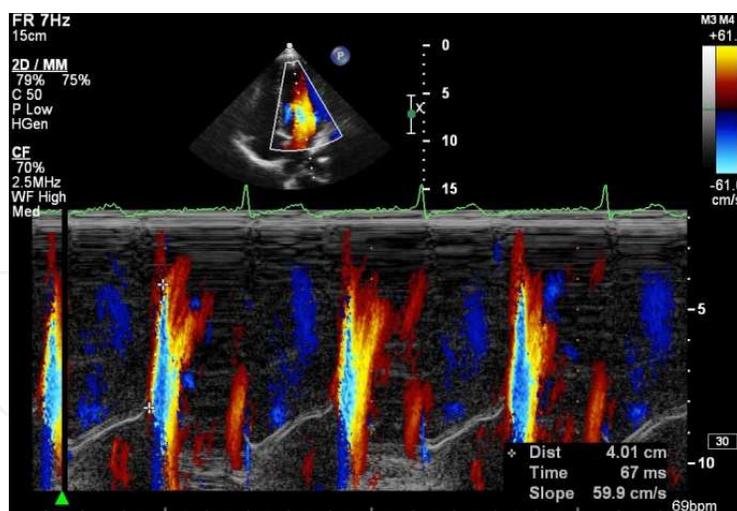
Color M-mode Doppler flow velocity propagation V_p , measured as the first color aliasing from mitral annulus to 4 cm into left ventricular cavity from 4-chamber apical view.
